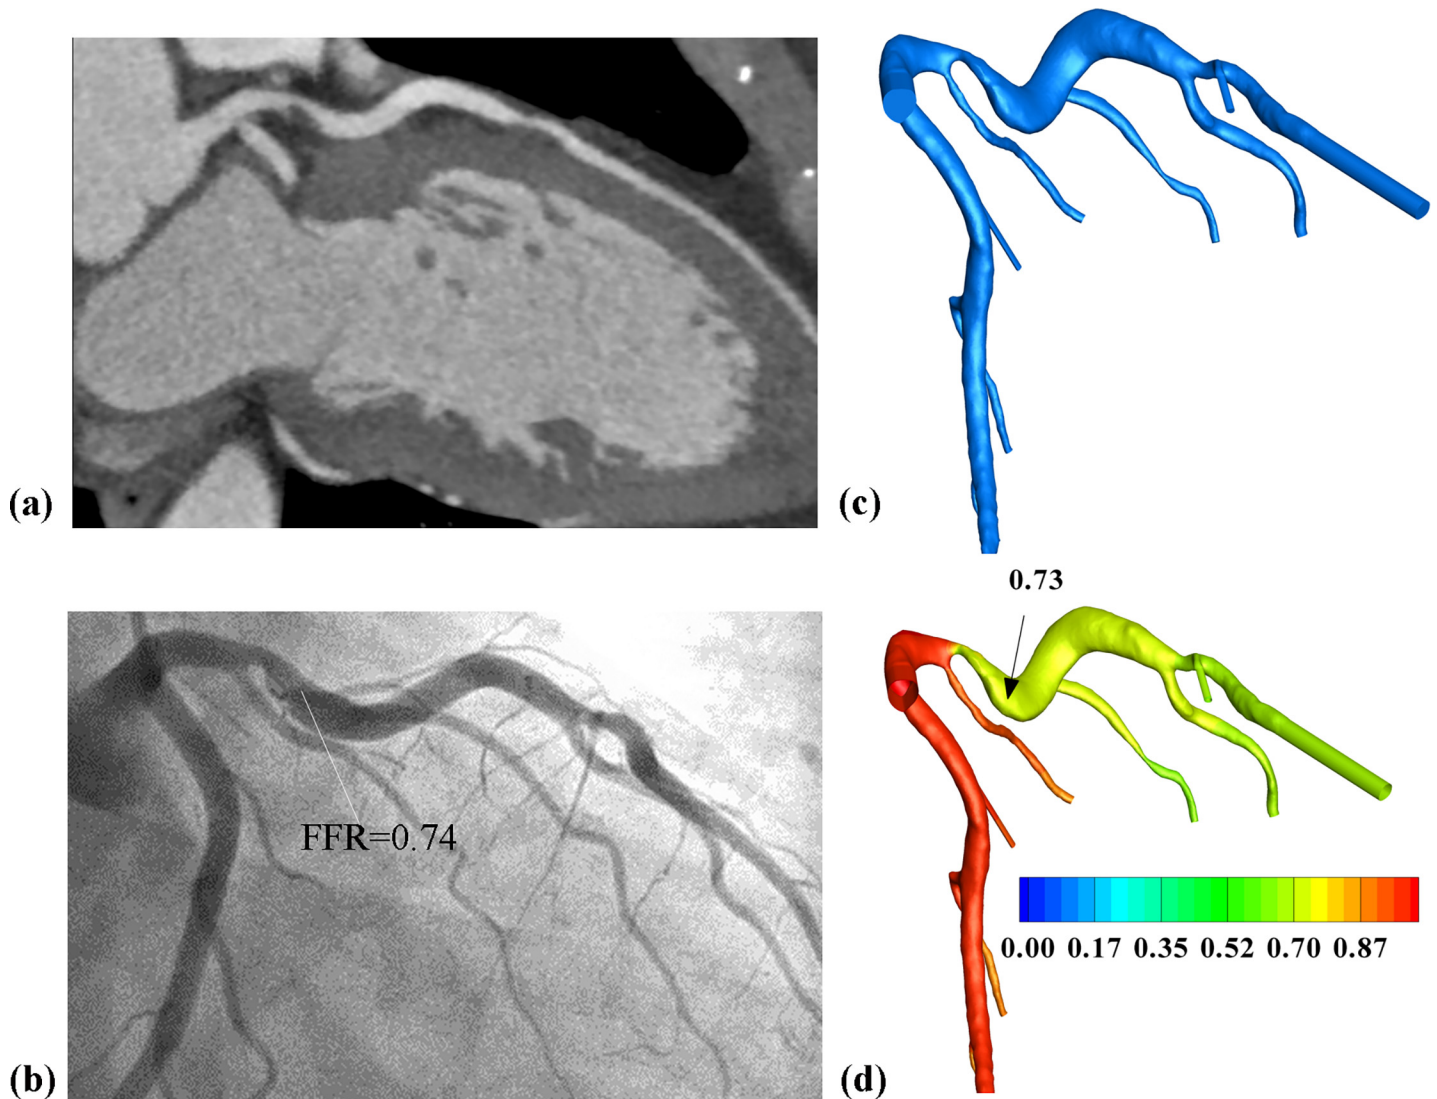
Representative patient with functional significant stenosis. Severe luminal stenosis was observed from (a) CTA images and (b) invasive angiography measured FFR at 0.74 ($FFR \leq 0.8$). Based on the (c) 3D model reconstructed from CTA images, CFD derived (d) pressure distributions on the 3D model and the calculated FFR_{SS} was 0.73.
